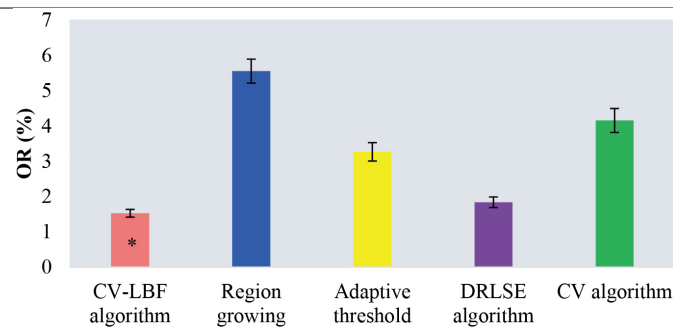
Comparison of OR values of CBCT images of teeth segmented by different algorithms.
